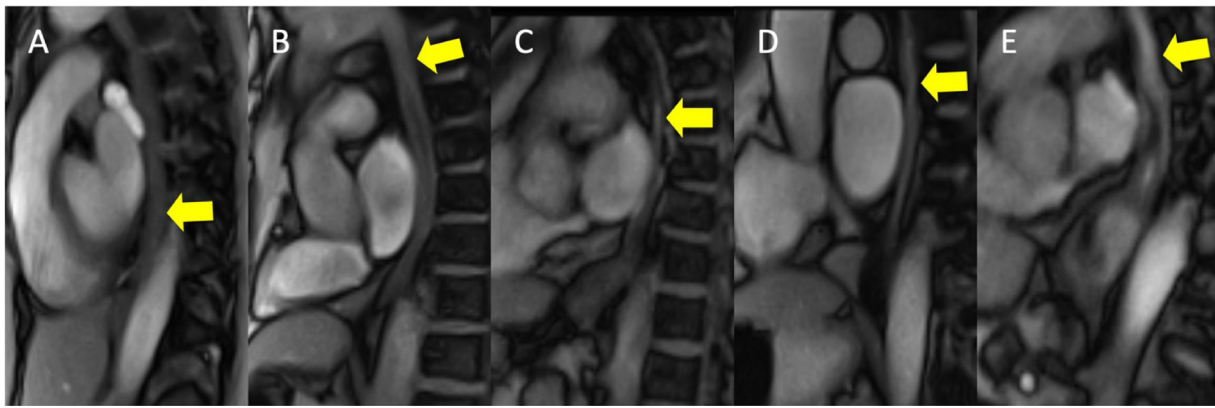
MRI reflux intensity on a five-level Likert scale according to esophageal signal increase during Valsalva maneuver. Patients with low signal intensity during Valsalva maneuver were graded 1/5 (A). Patients with marginal signal increase and flow-void were graded as 2/5 (B). Presence of fluid in a short section of the esophagus (arrow) was graded 3/5 (C). Continuous presence of fluid without distension of the esophagus was graded 4/5 (D). Large amounts of fluid with distension of the esophagus were graded as 5/5 (E).
